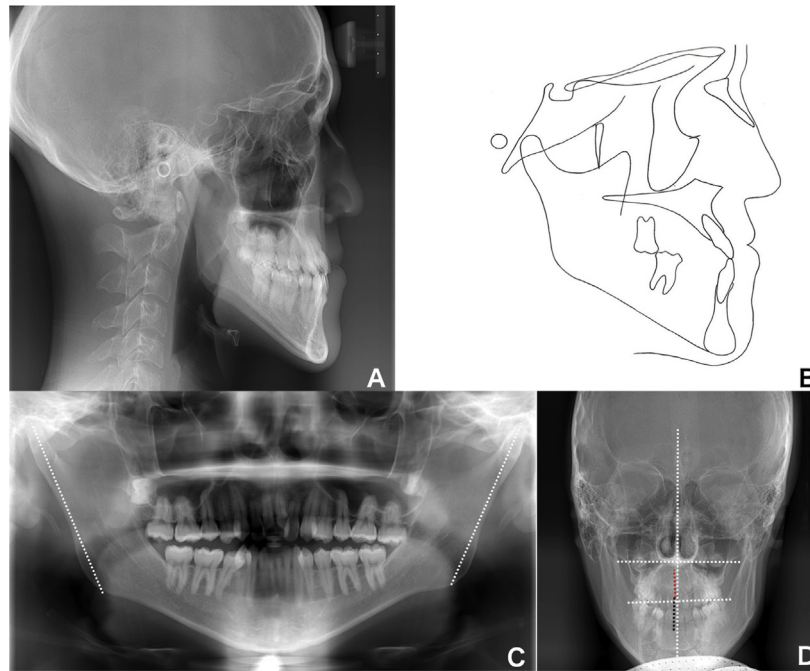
Patient 3: A-D, pretreatment cephalometric radiograph, cephalometric tracing, panoramic and PA radiographs. A substantial difference in the length of the condyle is observed (*white* in C). The cant of the occlusal plane (*white* in D), the dental midline of the maxilla (*red*), and the mandible (*black* in D) are indicated in the PA radiograph.
